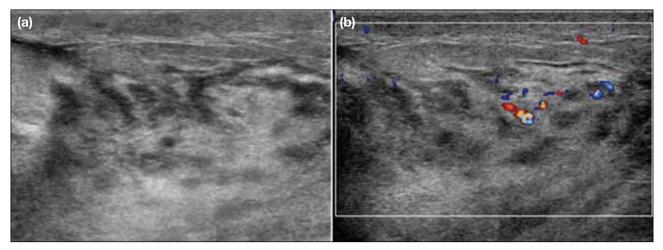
A 24-year-old female presented with fever and mastalgia for 5 days during breastfeeding. Physical examination found erythema in the lower outer quadrant of the left breast. Targeted ultrasound shows an ill-defined area of altered echotexture and loss of the normal parenchymal pattern (a). The subcutaneous fat appeared hyperechoic, while the glandular parenchyma was hypoechoic with increased central blood flow on colour Doppler (b). The overlying skin was thickened and hyperechoic. The features were suggestive of puerperal mastitis.
